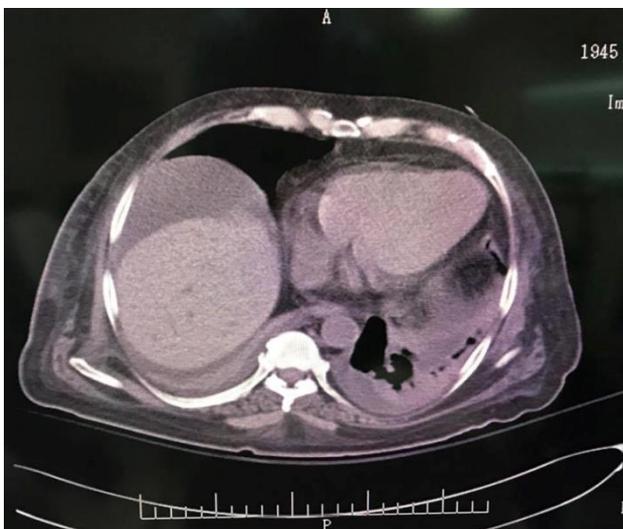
CT showing collection around the liver without pneumoperitoneum.
